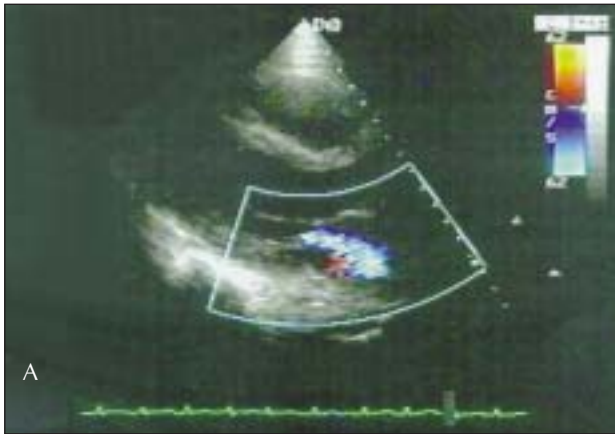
The transthoracic echocardiogram in the parasternal long-axis view depicts moderate mitral regurgitation (panel A) during atrial fibrillation, which disappears after cardioversion to sinus rhythm (panel B).
